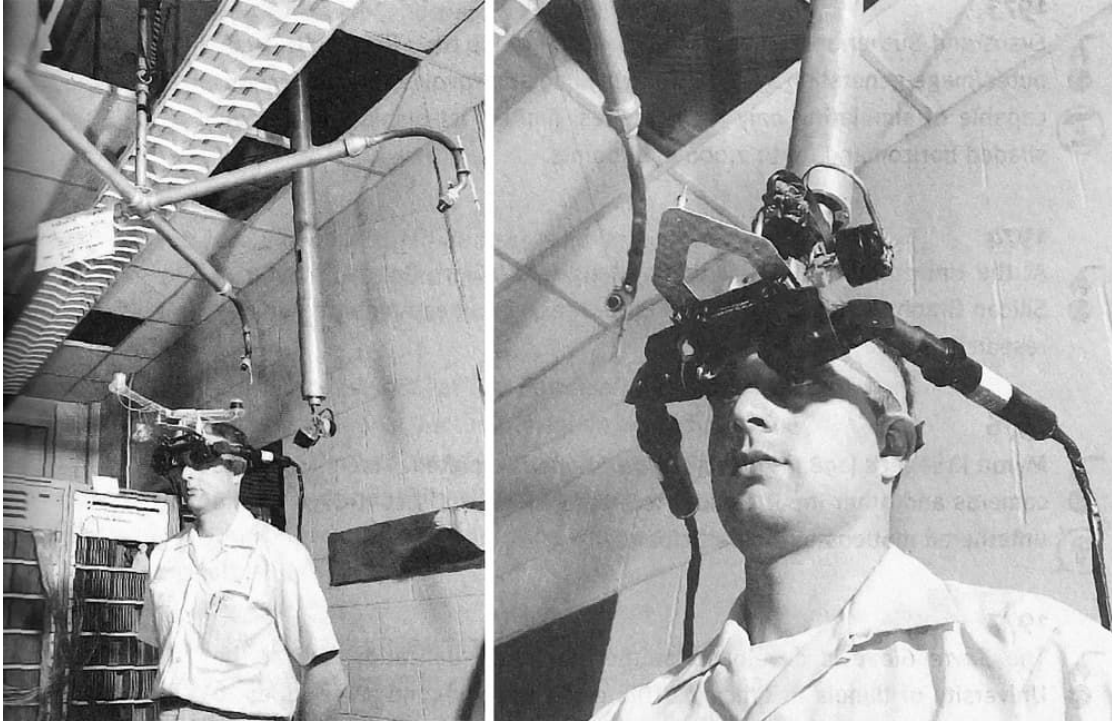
Ivan Sutherland's head-mounted 3D display (c. 1968). The display had a suspending counterbalance mechanical arm and used ultrasonic transducers to track the head movement. (Left) The system in use. (Right) The various parts of the three-dimensional display system. Images reproduced from Sutherland (1968), with permission from Dr. Ivan Sutherland.
